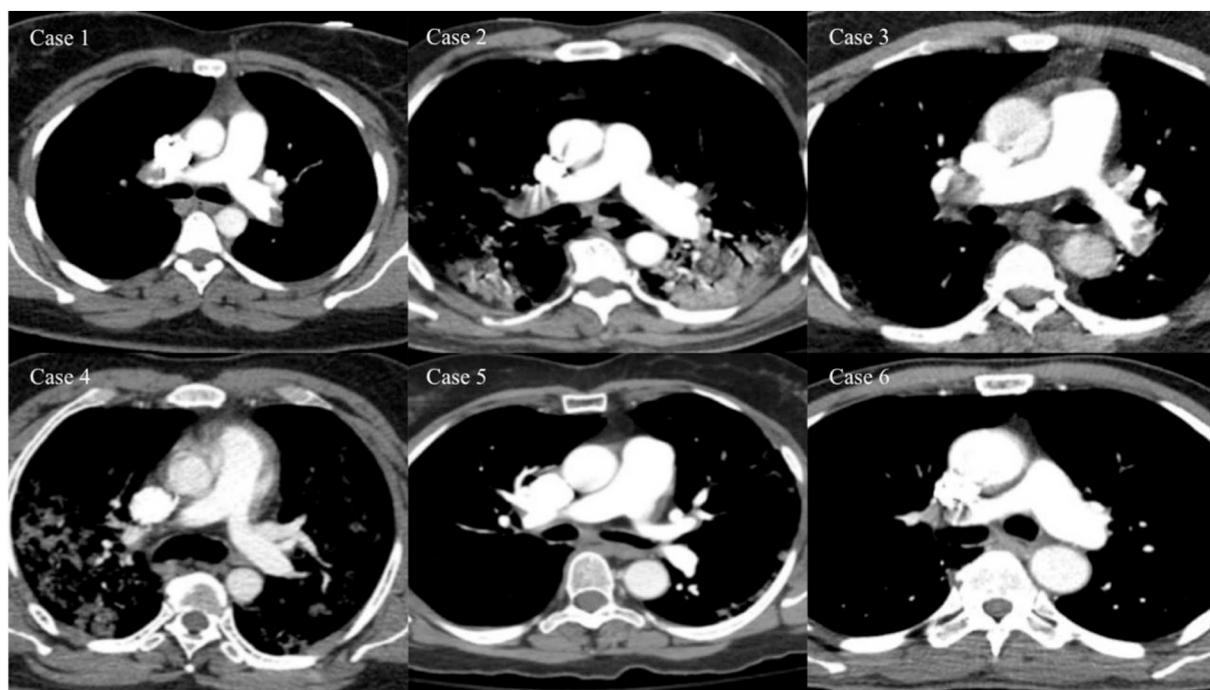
CTA images of the six patients.
